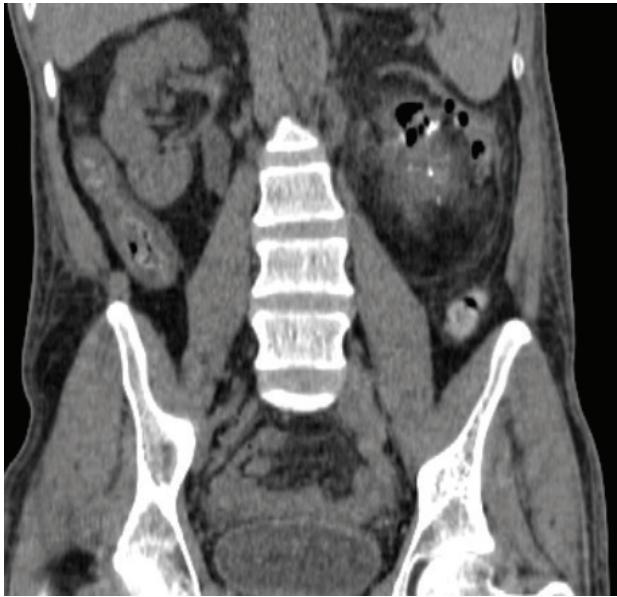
Coronal non contrast CT image.
